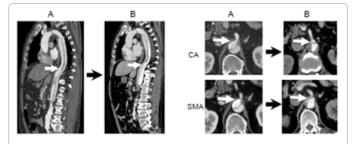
CT images compared on admission and 4 days later. A: Sagittal images show narrowing at the true lumen. B: Axial images at the CA and SMA level. The true lumen of CA and SMA are compressed by the false lumen. CA: celiac artery, SMA: superior mesenteric artery.
